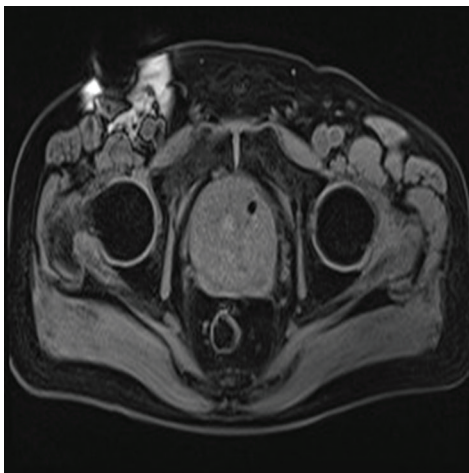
Prostate artery embolization pre-operative prostate magnetic resonance imaging. The image shows prostate hyperplasia; the prostate size is about $6.8 \times 5.4 \text{ cm}^2$
